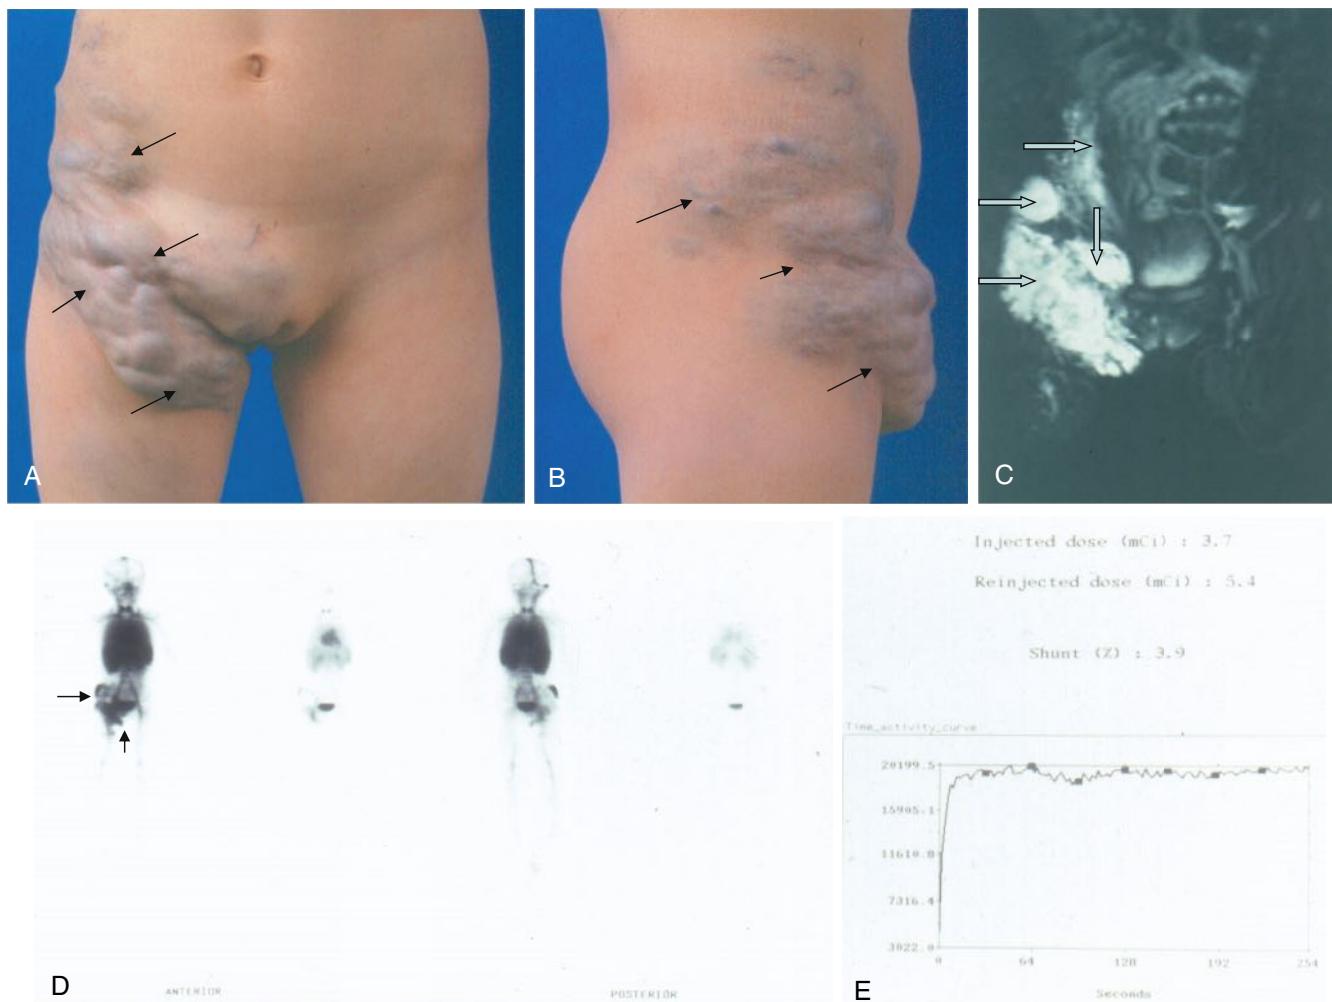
Preoperative Embolotherapy with N-Butyl Cyanoacrylate (NBCA). (A, B) This 4-year-old girl has a large venous malformation (VM) involving the skin along the entire right groin and extending to the upper thigh, lower flank, and pubis (arrows). (C) MRI shows a large infiltrating VM that is extremely vulnerable to trauma and bleeding (arrows). (D) Whole-body blood pool scintigraphy depicts the magnitude of the lesion affecting the entire right pelvic region (arrows). (E) Transarterial lung perfusion scintigraphy rules out a hidden arteriovenous malformation as a source of abnormally increased blood flow along the right lower extremity. There is no evidence of shunting – 3.9% is within the normal range.
